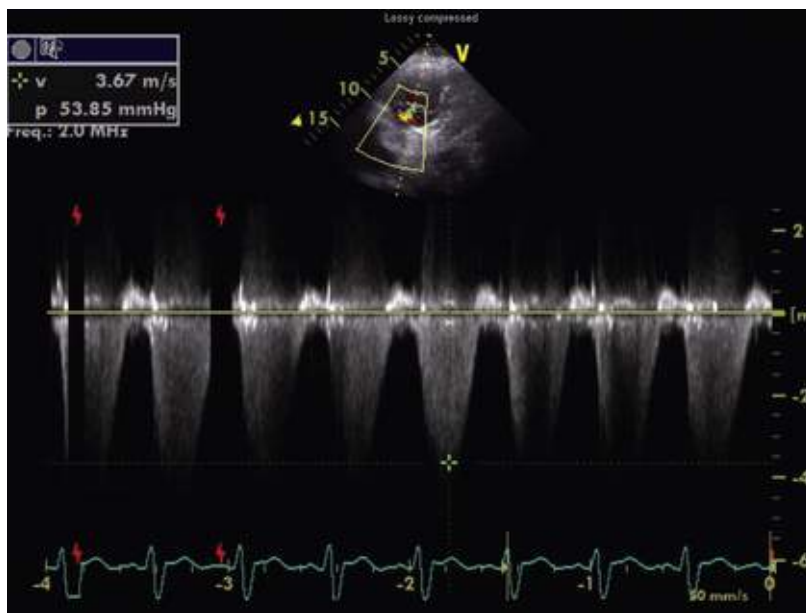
Doppler echocardiographic tracing obtained in a patient with submassive PE. The estimated pulmonary artery systolic pressure is 54 mm Hg, with an additional contribution of right atrial pressure, resulting in moderately severe acute pulmonary hypertension.
